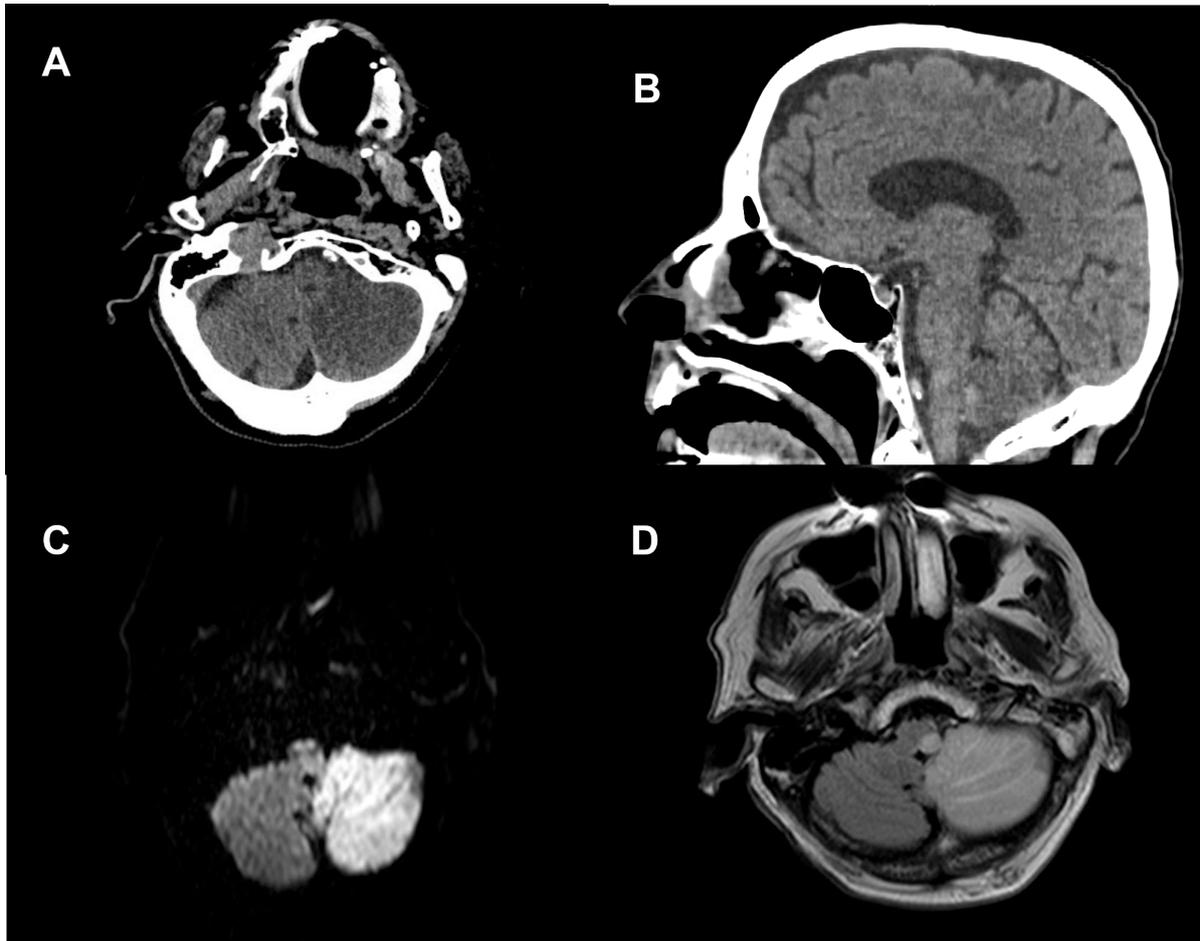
Panel 1,2, 3, and 4. 1-A and 1-B non-enhanced CT scan showing a posterior fossa tumefactive hypodense lesion in the left cerebellar hemisphere and cortical and subcortical atrophy. 1-C Diffusion-weighted imaging (DWI) revealed restriction in the left cerebellar hemisphere. 1-D FLAIR sequence with a hyperintense lesion involving the left cerebellar hemisphere and dorsolateral medulla.
